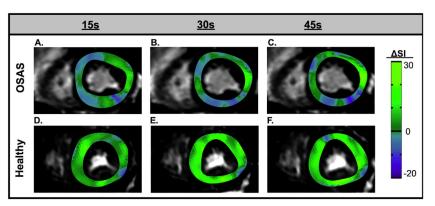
Color maps of signal intensity changes in oxygenation-sensitive cardiovascular magnetic resonance images in a patient with obstructive sleep apnea syndrome (OSAS) and a healthy subject. Subtraction image of signal intensity changes from baseline to the three time points within the breath-hold (15 s, 30 s, and 45 s). The signal intensity increase is more pronounced in the healthy subject (top row) as compared to the patient with OSAS (bottom row).
